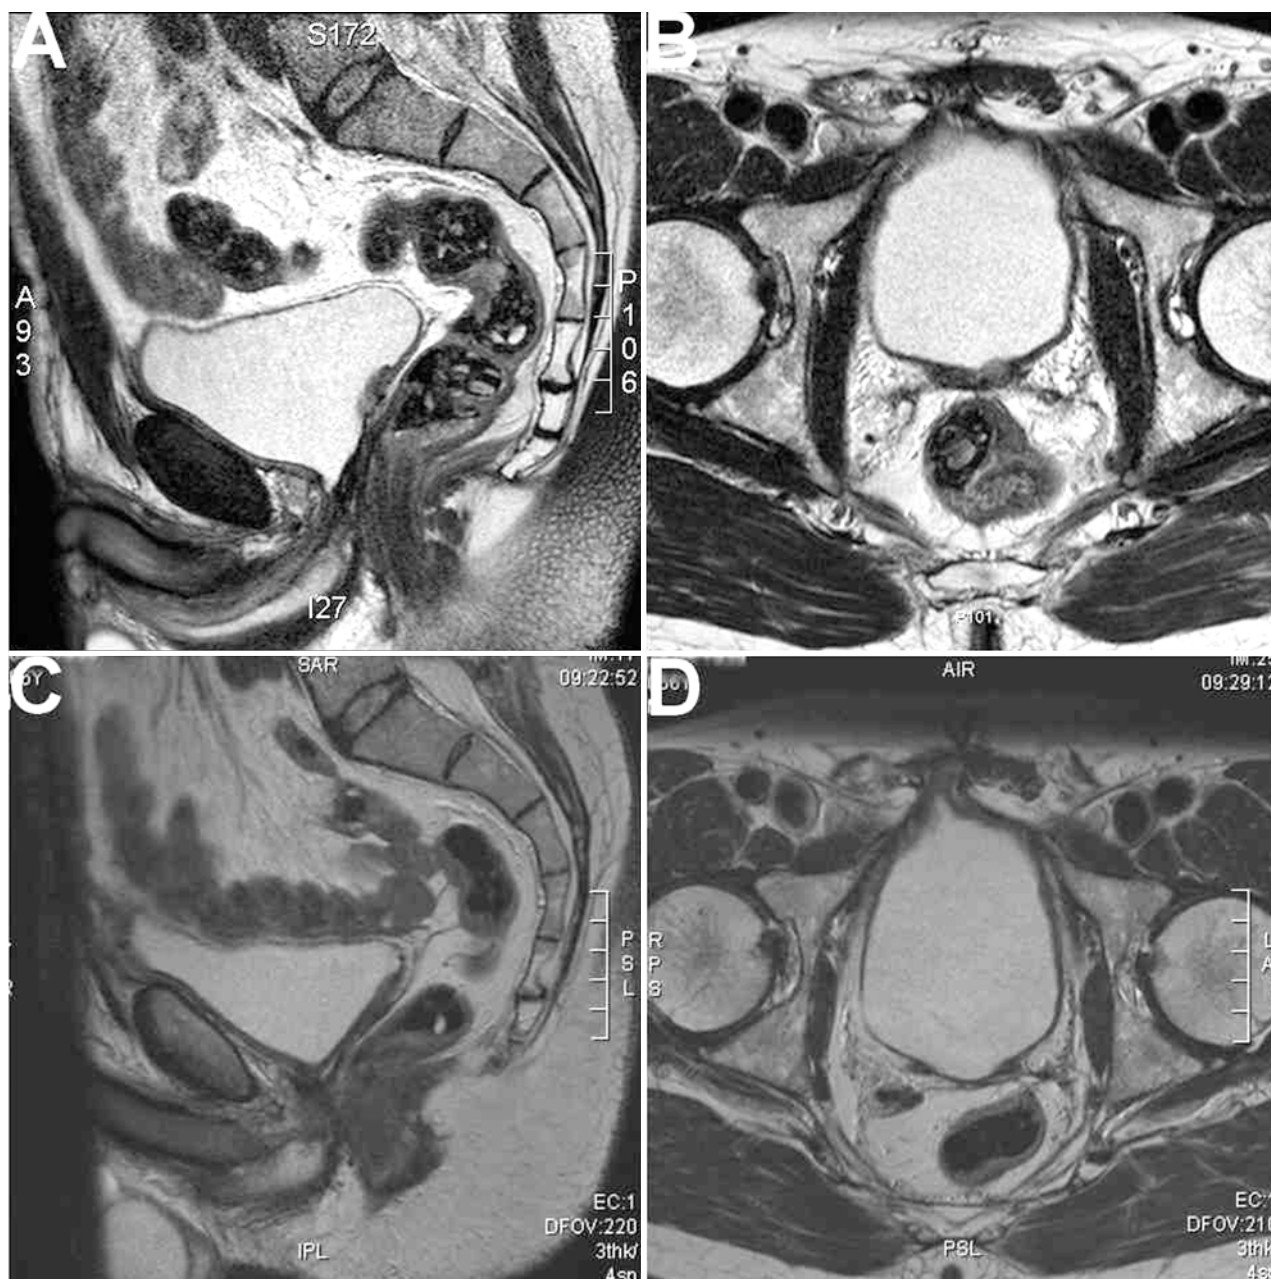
A and B, Magnetic resonance imaging (MRI) five years following radical prostatectomy shows a 14 mm x 10 mm x 10 mm suspicious mass at the posterior wall of the urinary bladder 3 cm cranial the bladder neck. There are no additional suspicious lesions in the pelvis. C and D, MRI six months following the resection of the tumor. There are no signs of residual tumor.
